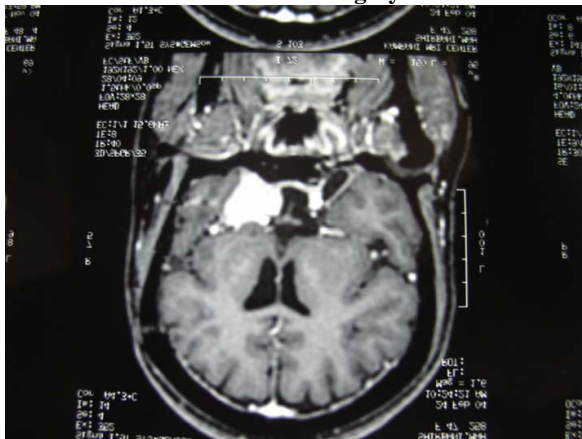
MRI imaging in a case of Meningioma before and six months after the surgery.
